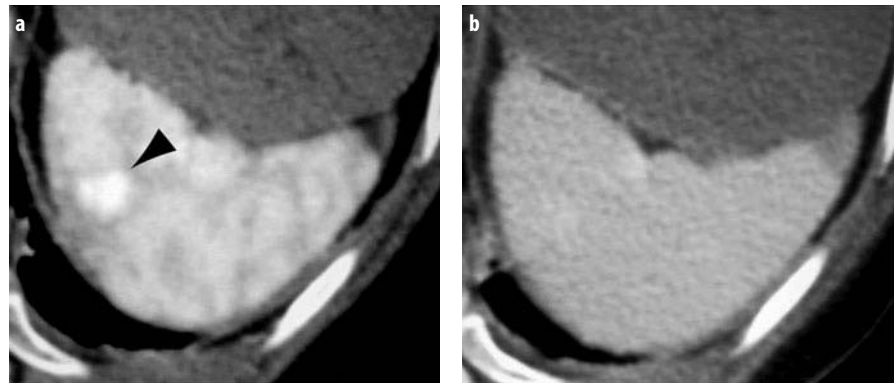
a, b. Blunt trauma. a Routine trauma CT image shows area of hyperdensity (*arrow-head*). b Delay image shows that the hyperintensity is no longer visible; the lesion has become isodense with blood pooling, indicating confined pseudoaneurysm rather than free active bleeding
